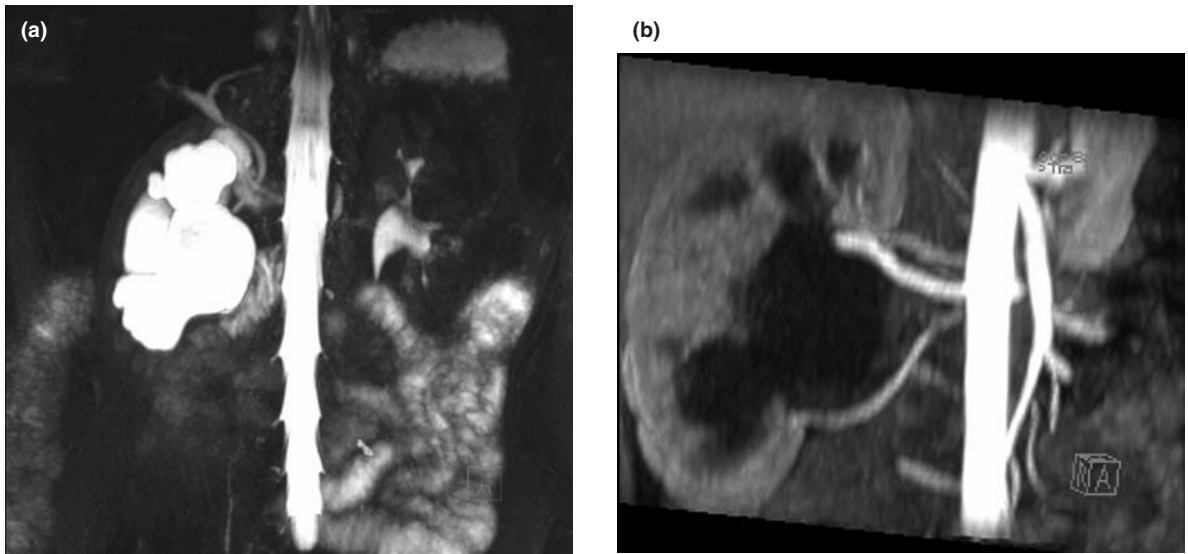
MRI in a patient with a 'crossing vessel' causing pelviureteric obstruction. (a) The heavily T_2 -weighted sequence shows the marked hydronephrosis of the right kidney. (b) A T_1 -weighted sequence after gadolinium shows the main right renal artery but also an accessory right renal artery 'crossing' the distended renal pelvis to cause the right pelviureteric junction obstruction. MRI has shown both the renal pelvic anatomy and the dynamic vascular anatomy in the same examination.
